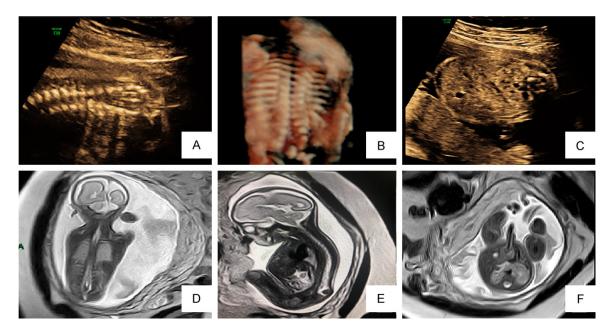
CRS, 30 weeks pregnant. A. Sagittal 2D ultrasound view of the fetal lower spine showing a defect in the lumbosacral vertebral body and intraspinal lipomas. B. Coronal section 3D ultrasound view of the fetal lower spine showing a defect in the lumbosacral vertebral body and intraspinal lipomas. C. Transverse view showing the fusion of the lower poles of both kidneys in front of the spine, presenting as "horseshoe kidneys". D. Coronal SSFSE-T2W1 intraspinal lipoma with longitudinal spinal cord fissure. E. Sagittal SSFSE-T2W1 of the fetal lower spine showing a defect in the lumbosacral vertebral body and intraspinal lipomas. Abbreviations: CRS, caudal regression syndrome; 3D, three-dimensional. F. Axial SSFSE-T2W1 showed that the lower poles of both kidneys were connected.
